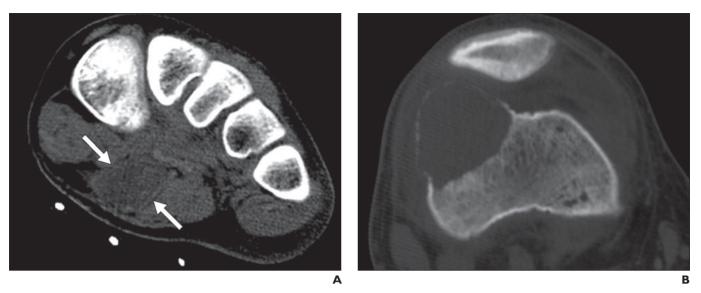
Images show example of soft-tissue lesion with nonspecific imaging appearance and bone lesion with characteristic imaging appearance. A, Hypoattenuating soft-tissue mass in plantar aspect of foot (*arrows*), without specific radiographic features in 13-year-old boy. CT biopsy results were suggestive of hemangioma, but open biopsy was required for confirmation.
